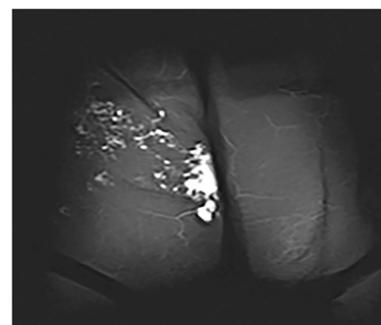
MRI with contrast demonstrating gluteal involvement of venous malformation.
